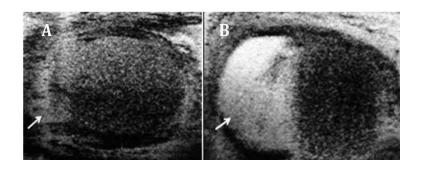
Ultrasonography of the right testicle in A, showing 10 ml volume and normal structure; B=right scrotum ultrasonography showing scrotal oedema
